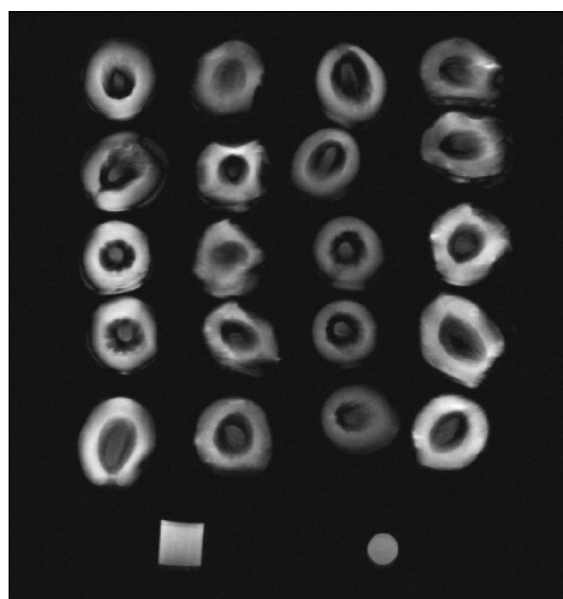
MR water suppression images for all varieties with 5 replica; *Mega* is first column at the left, *Light* is second column at the left, *Ayvalik* is second column at the right, *Sele* is first column at the right. Above the MR image, there are two reference samples to increase signal to noise ratio.
